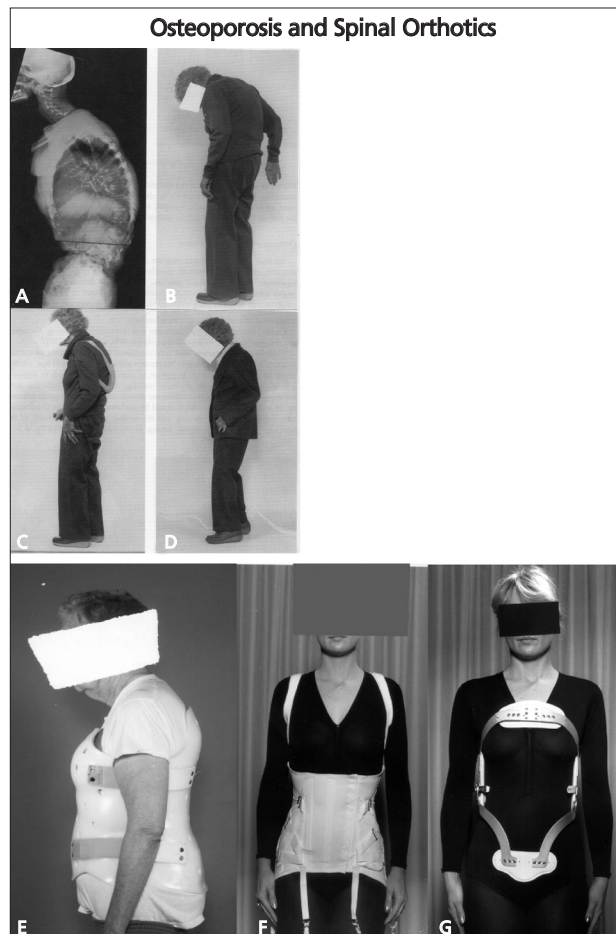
A, B: Radiograph and photo of an 86-year-old woman with severe osteoporosis that made her ambulation difficult
